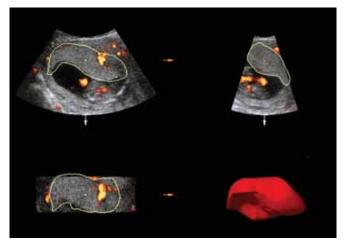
Transvaginal 3D US power Doppler assessment of the placenta at the first trimester. Placental volume and vascularization can be calculated easily using the virtual organ computer-aided analysis (VOCAL) program
